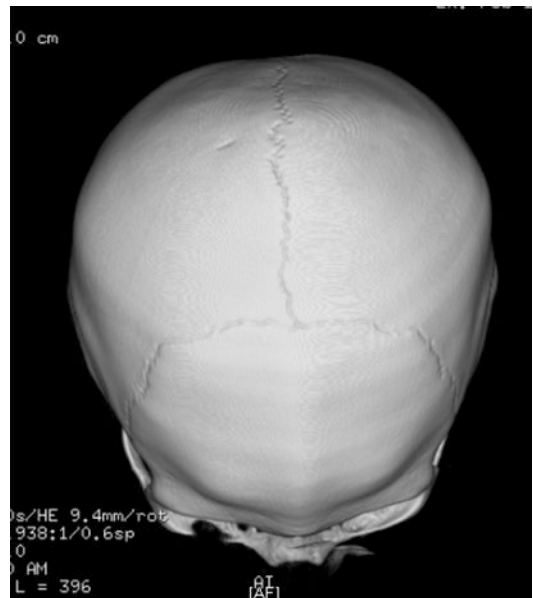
3D computed tomography image of an infant with metopic craniosynostosis which resulted in trigonocephaly
